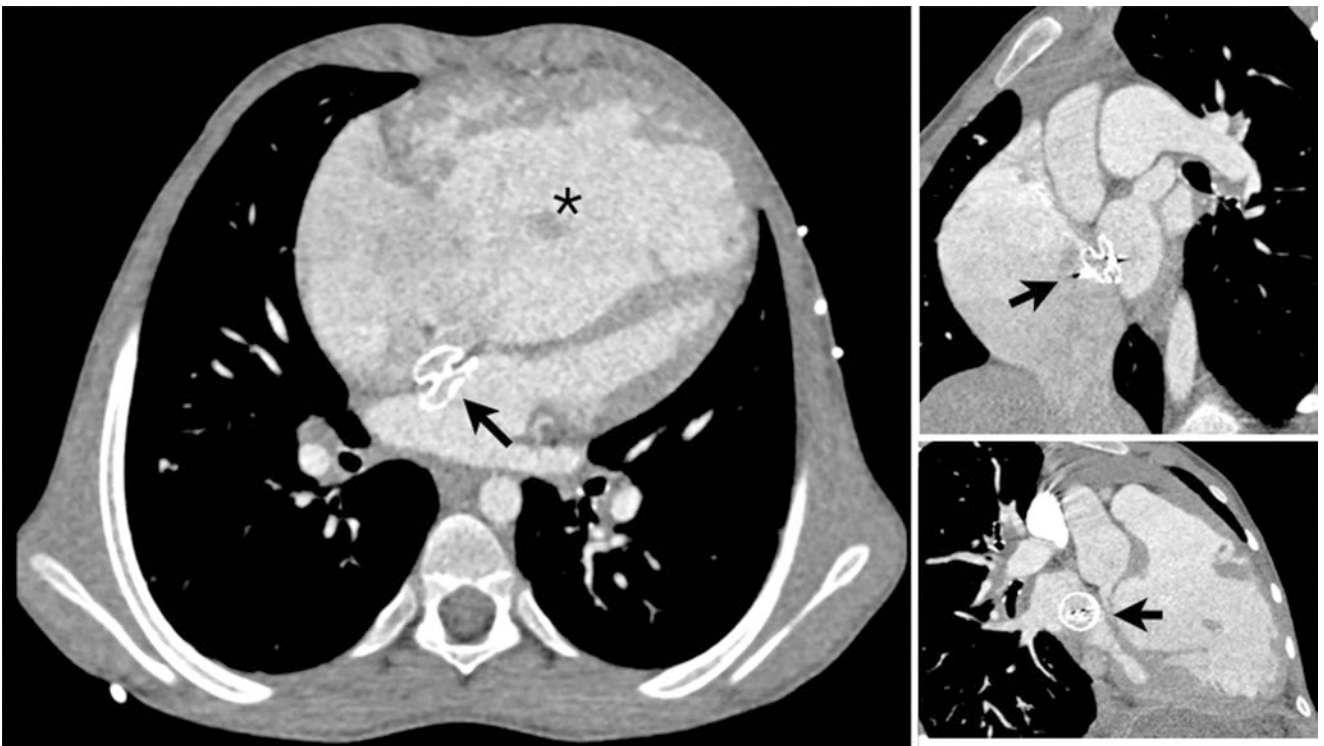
Atrial septal defect device in a 30-year-old, contrast-enhanced CT. Left image shows an axial four-chamber view. ASD device seen in atrial septum (arrow). Note the marked dilatation of the right ventricle (*) and the right atrium. Right upper image shows an
